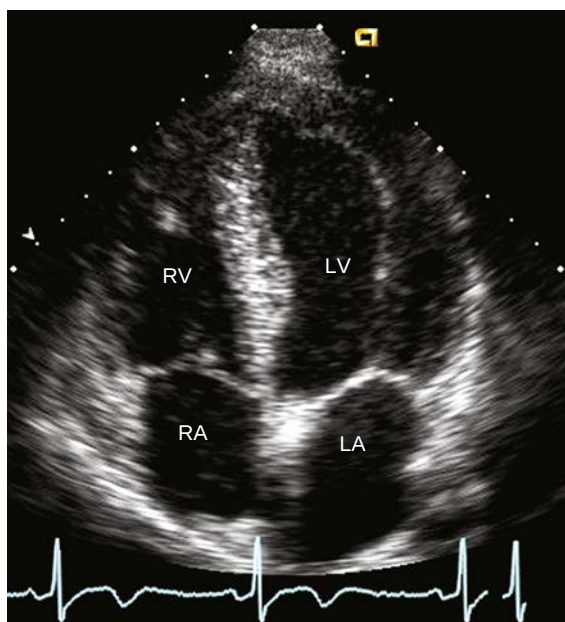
Apical 4-chamber view. The transducer is correctly positioned over the LV apex as shown by the longer LV length than width and ellipsoid shape of the chamber. Foreshortening of this view results in a more spherical appearance of the LV. This older adult has both enlargement of atrium and some benign thickening (lipomatous hypertrophy) of the atrial septum. The loss of signal in the mid-segment of the atrial septum is an artifact, because the thin fossa ovalis is parallel to the ultrasound beam at this point resulting in echo “dropout.”
